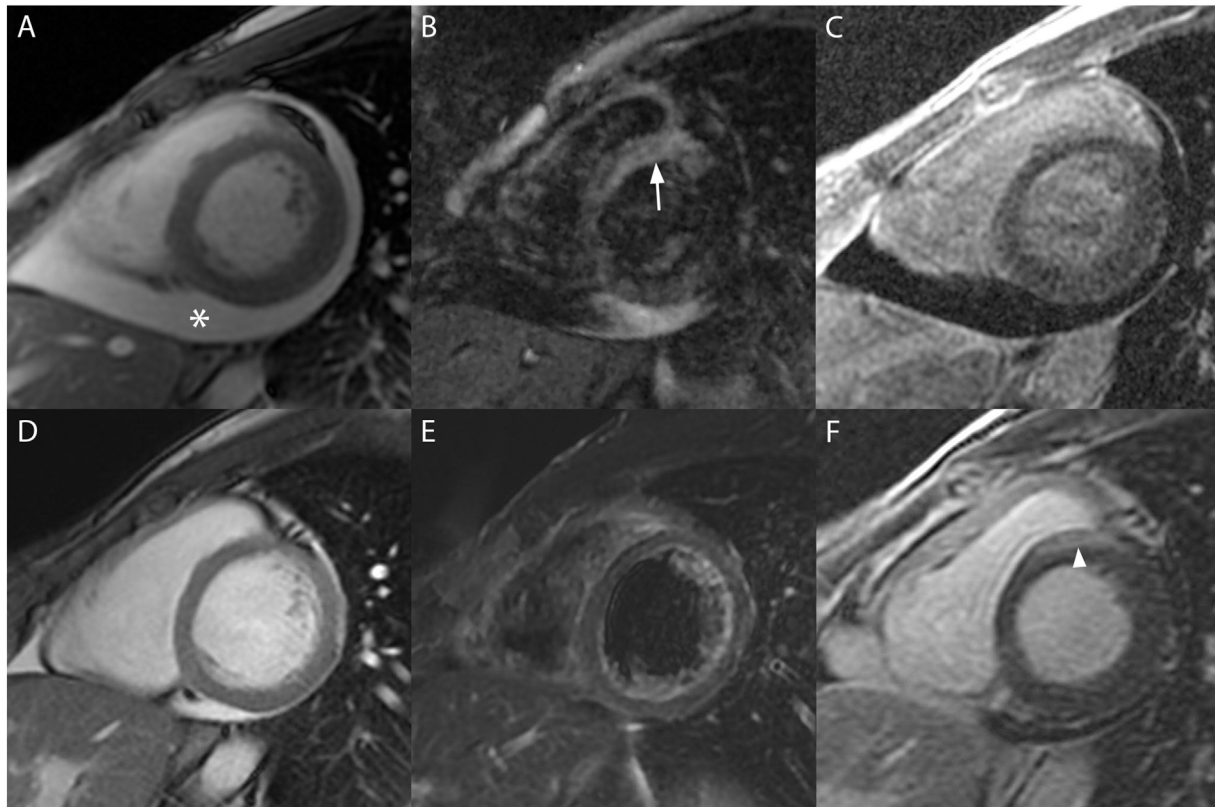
First (A–C) and second (D–F) CMR scan, acquired clinically during acute myocarditis and in an out-patient setting after 6 months of follow-up respectively. On the first scan, the short-axis cine (A) and triple-inversion recovery T2-weighted (B) CMR images showed circumferential pericardial effusion (asterisk) and myocardial edema in the basal anteroseptal wall (arrow), while the delayed enhancement sequence gave the impression of a thin line of gadolinium retention in the same area (C), that could however not easily be distinguished from the blood pool in the right ventricle. After 6 months, the short-axis cine (D) and double-inversion recovery T2-weighted (E) CMR images showed almost no more pericardial effusion and complete resolution of the myocardial edema, while an area of mid- to epicardial delayed enhancement (F) was now clearly delineated in the same region (arrowhead).
